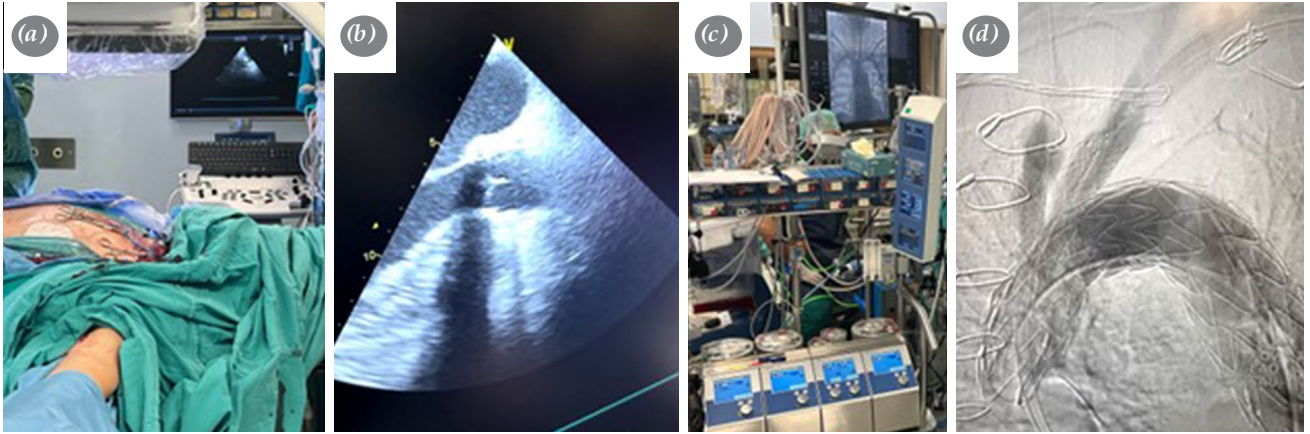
Operative details. (a, b) Transesophageal echocardiography was placed preoperatively and helped physicians the precise deployment period; the tip of the stent graft delivery kit was advanced through the aortic valve into the left ventricle. (c) Extracorporeal circulation for selective cerebral bypass machines. (d) Angiogram during the procedure is demonstrated.
